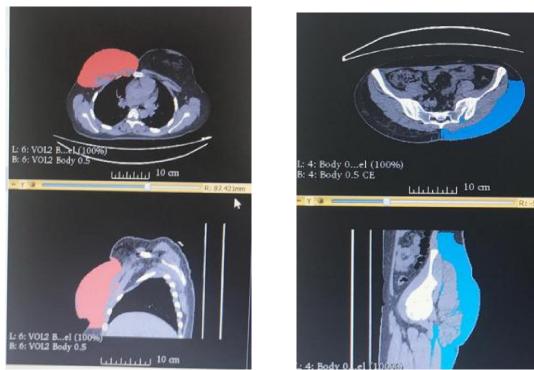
volumetric CT for fat (breast)
